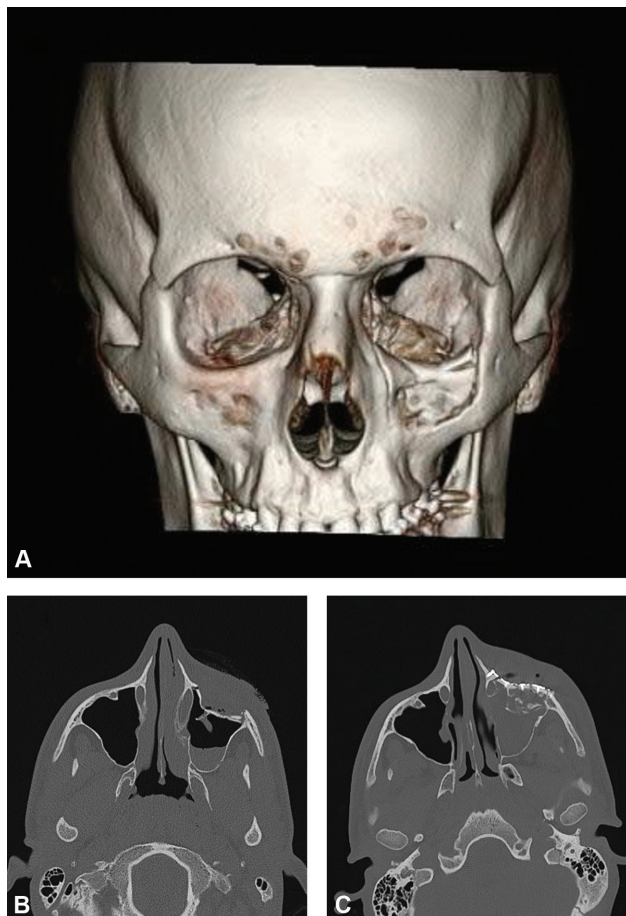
(A) Maxillofacial CT with 3D reconstruction demonstrating the comminuted nature and contour deformity of the left inferior orbital rim and anterior maxilla. (B) and (C) demonstrate the contour deformity of the left rim and anterior maxilla prior to and after open reduction and internal fixation using VSP and 3D printing.
